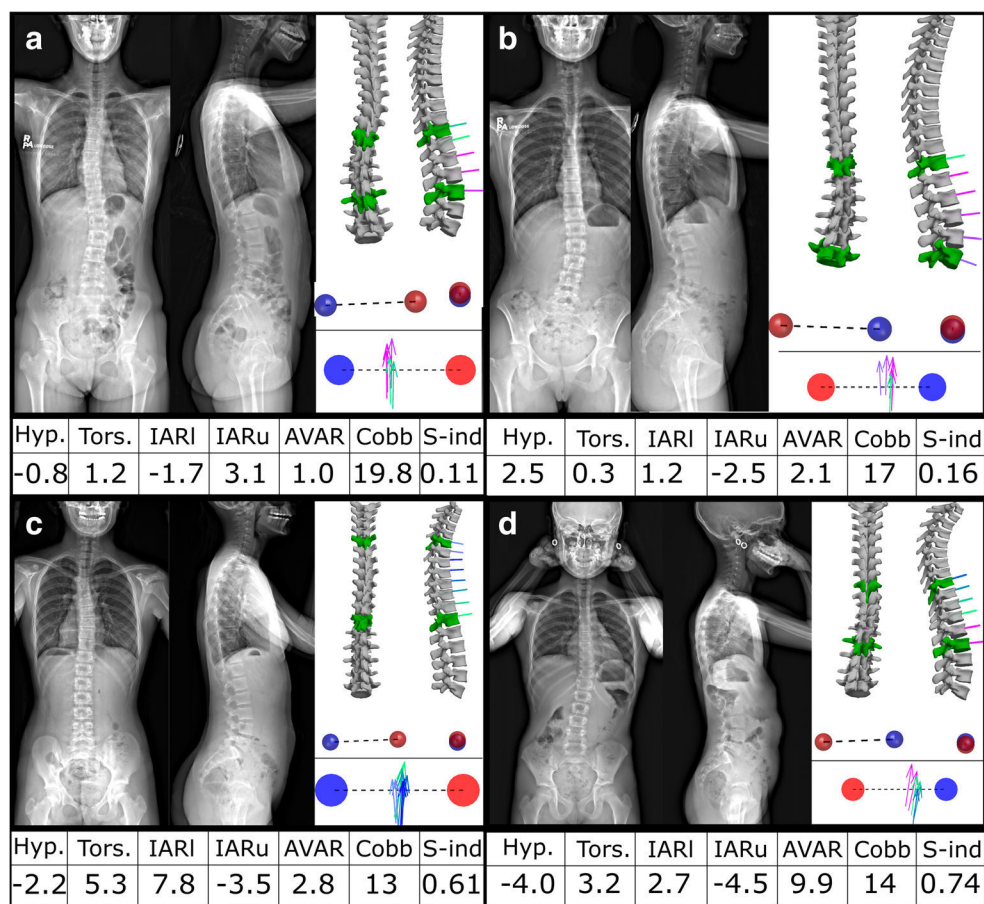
Examples of two stable patients (a, b) and two progressive ones (c, d). Each panel shows the patient's biplanar radiography at inclusion, the 3D reconstruction of the spine, and pelvic acetabula. A top view of the scoliotic curve was also included where the vertebrae were represented as vectors as proposed by Illes et al [27]. a A 12-year-old girl with moderate Cobb angle (19.4°), but with normal hypokyphosis index (1.1°; a normal index would be 0°) and low intervertebral rotations at the end vertebrae; it was correctly classified as stable by the severity index despite the high Cobb angle. b A 15-year-old girl who also has a high Cobb angle of 17°, but a normal lordosis and low axial rotations, so she was correctly
